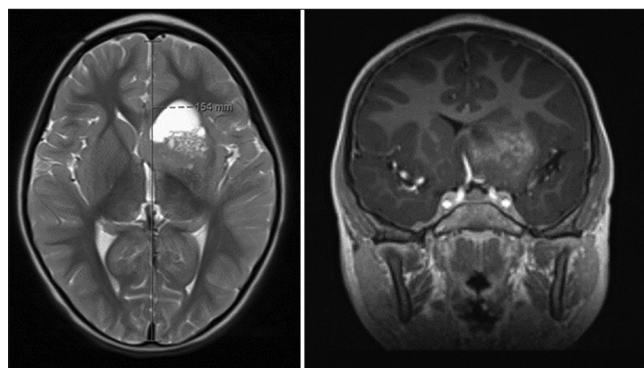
Follow-up magnetic resonance imaging demonstrating a cystic and solid mass lesion in the left inferior frontal gyrus associated with a cluster of enhancing microcystic lesions as well as a thick rim of restricted diffusion most conspicuous along the inferior medial aspect.
